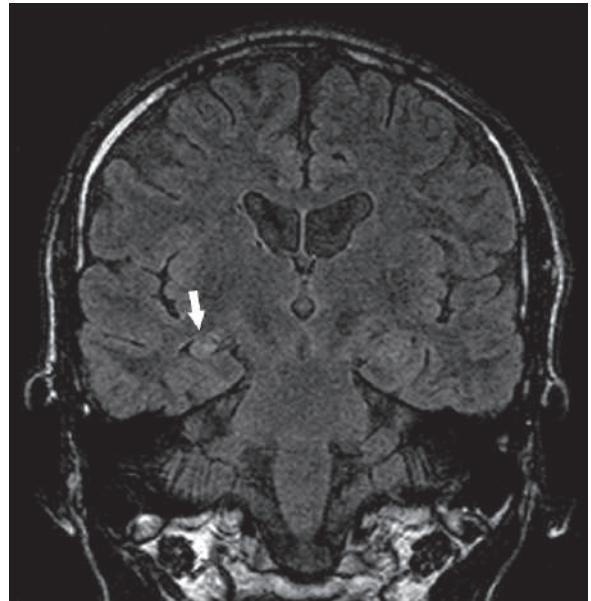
Coronal T2W brain MRI of a patient with recurrent epilepsy shows mild atrophy of the right hippocampus with higher T2 signal intensity (arrow) compared to the left side (mesial temporal sclerosis)
